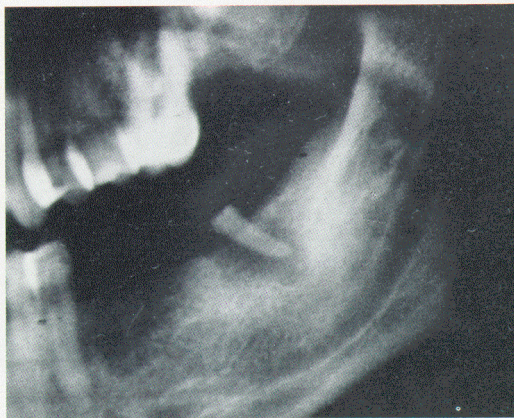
Radiograph of a patient with an acute abscess in the lower jaw associated with a retained tooth root.
